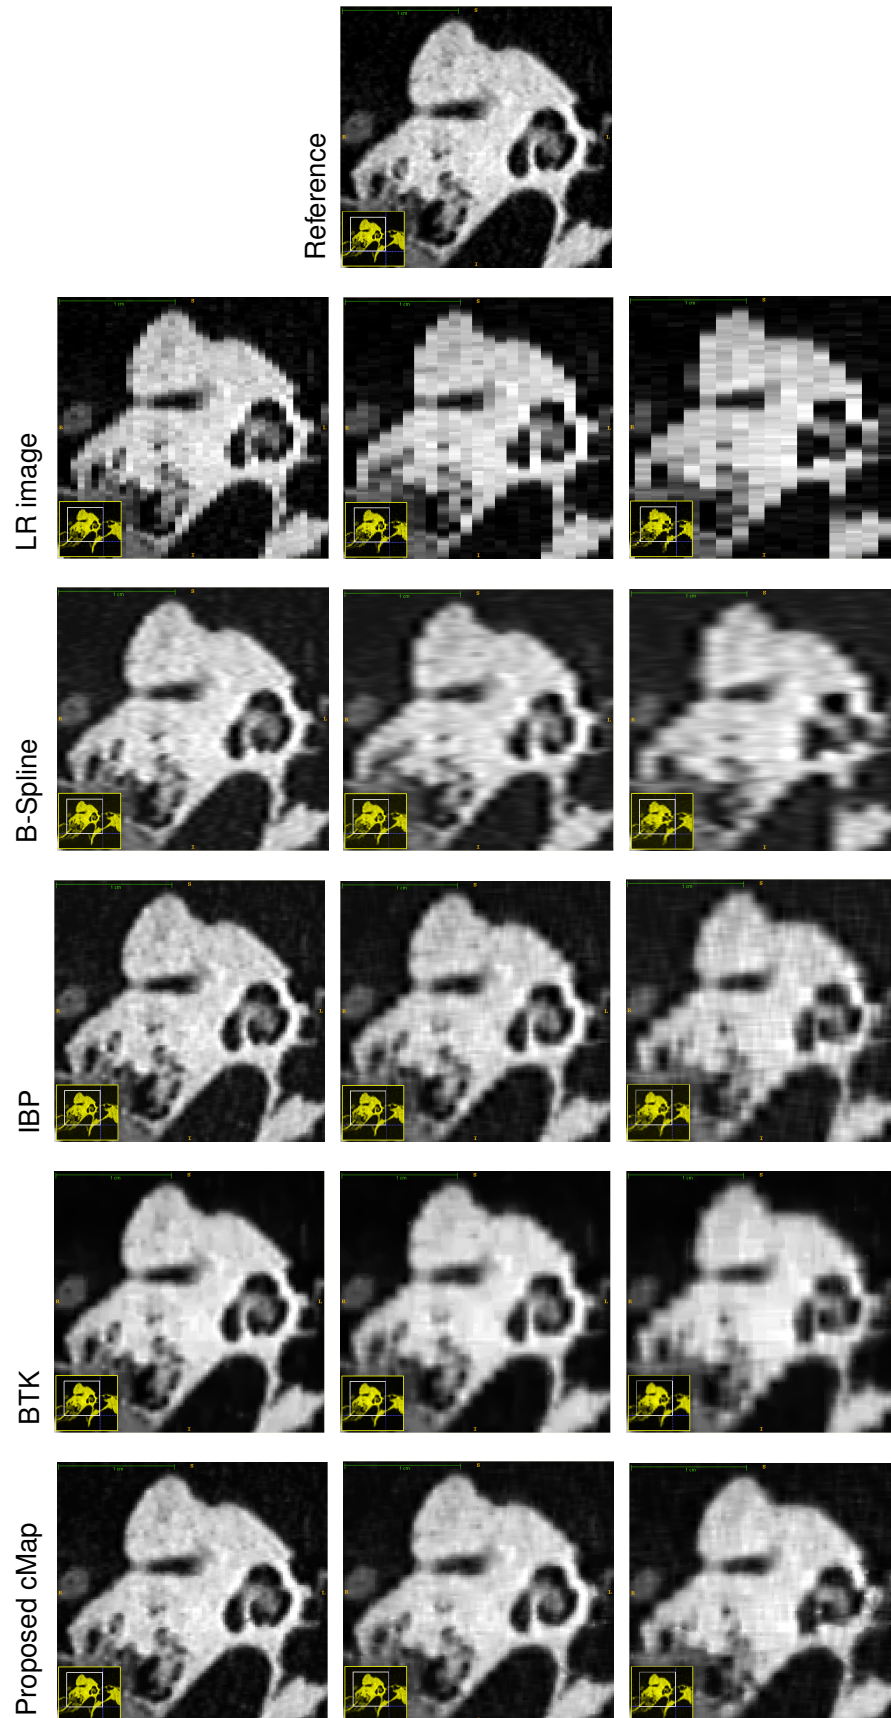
Comparing reconstruction quality after applying various SRR techniques. The downsampling factors are 3 (left), 5 (middle), and 7 (right). The reference image was acquired with an industrial CT scanner
